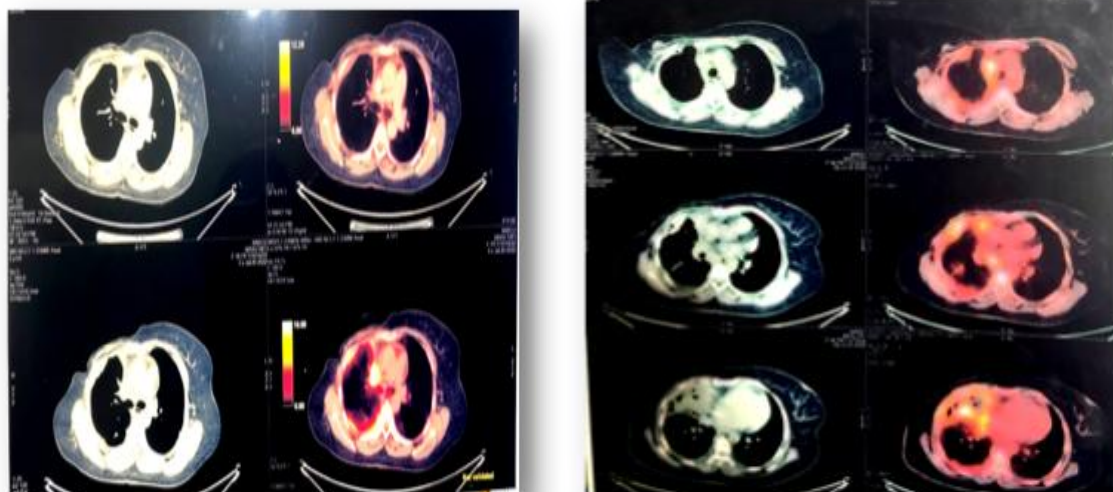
and b showing PET CT scan depicting FDG avid deposits in almost entire lung pleura, largest measuring 5.2 x 2.6 x 4.3 cm (SUV max 11.28). Fat stranding and ulceration in right chest wall is shown in figure 1b with significant uptake. Multiple FDG avid mediastinal lymph nodes likely to be metastatic
